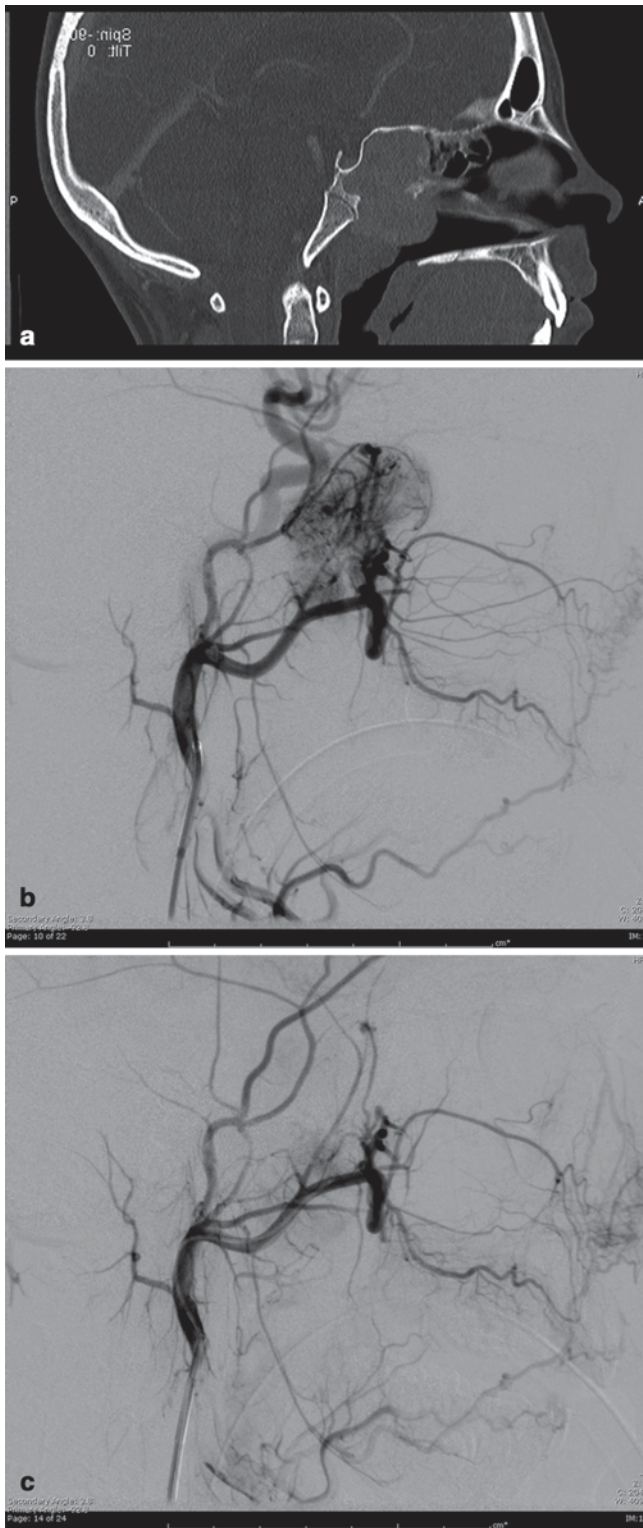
Juvenile nasopharyngeal angiofibroma (JNA): a Sagittal CT-reconstructed image of the head demonstrates large enhancing nasopharyngeal mass. b Selective internal maxillary artery injection demonstrating hypervascular nasopharyngeal mass. c After selective embolization with PVA particles, there is near-complete cessation of flow to the mass with preservation of the normal circulation
